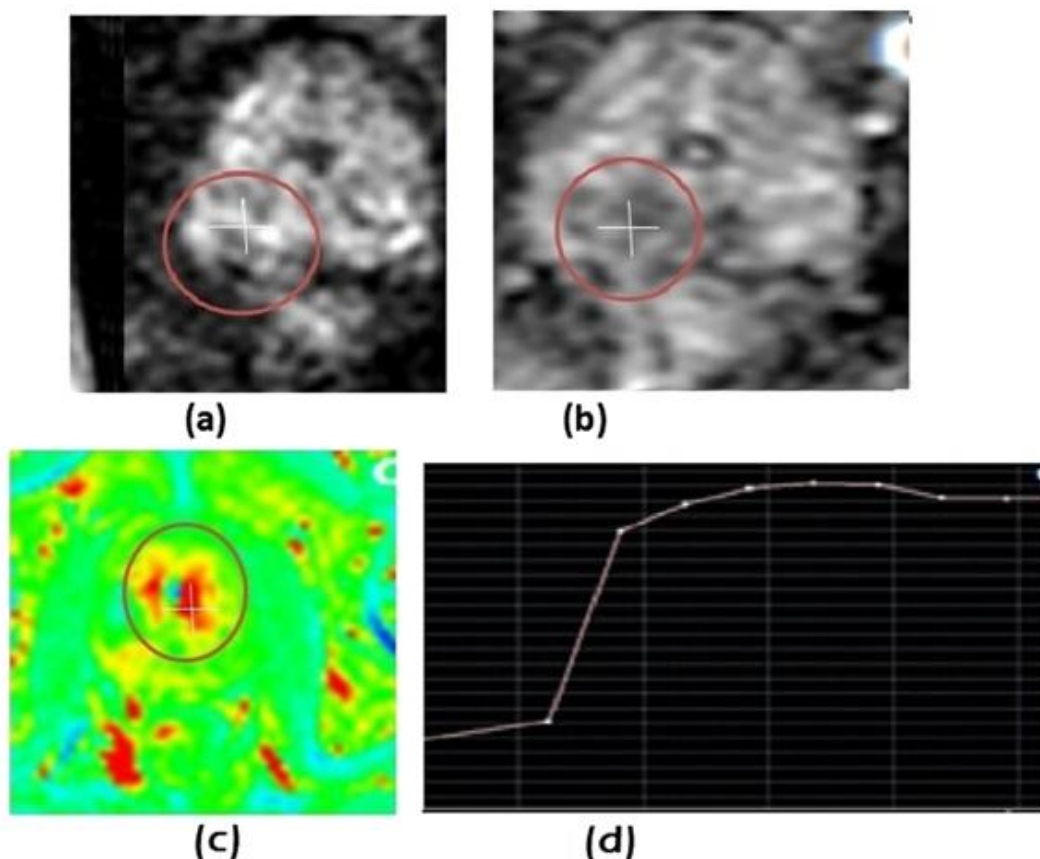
69 yrs old patient, with hard suspicious Rt. prostatic nodule felt by P/R (a and b) DWI and ADC map revealed moderate diffusion restriction at Rt. side peripheral zone lesion (red circle), ADC value “0.958.93”, (c and d) DCE-MRI revealed mild enhancement with type II enhancement curve. PI-RADS 2.0 score = 3. All MP-MRI findings are collectively diagnostic of mostly Malignant lesion. Histo-pathology: Adeno-Ca. (Gleason score 8).
